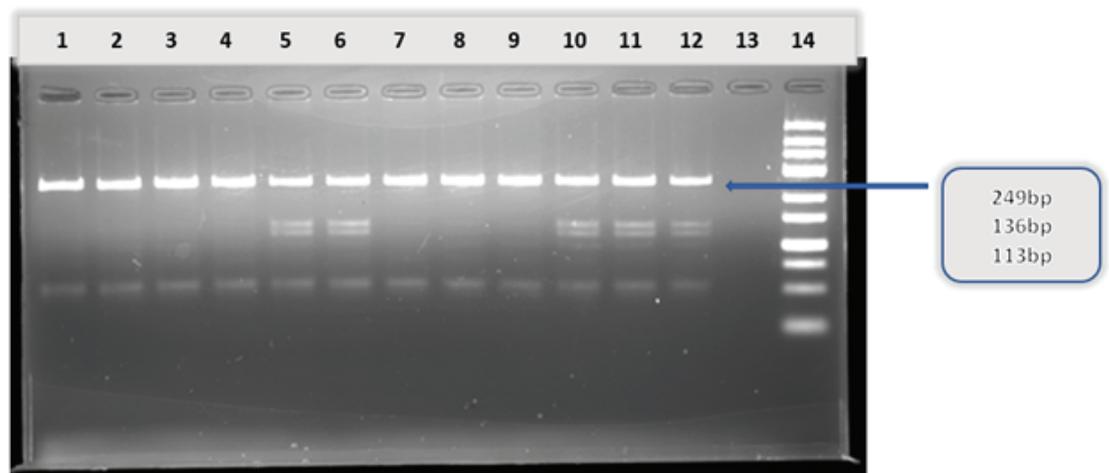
Lanes 1–4 and 7–9 are uncleaved wild-type homozygous CC (249 bp), lanes 5, 6, and 10–12 are heterozygous CT mutant (249, 136, 113 bp), lane 13 is negative control, and lane 14 represents the 25 bp DNA ladder.
